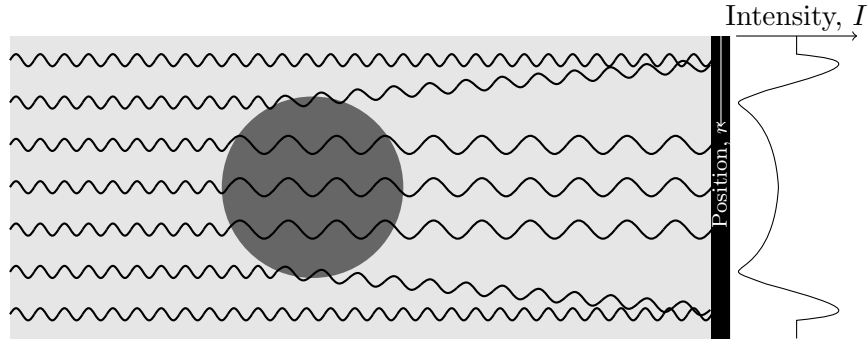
Phase created by the refraction of x-rays at the edges of the object. Based on figure from Burvall et al. [2011]
